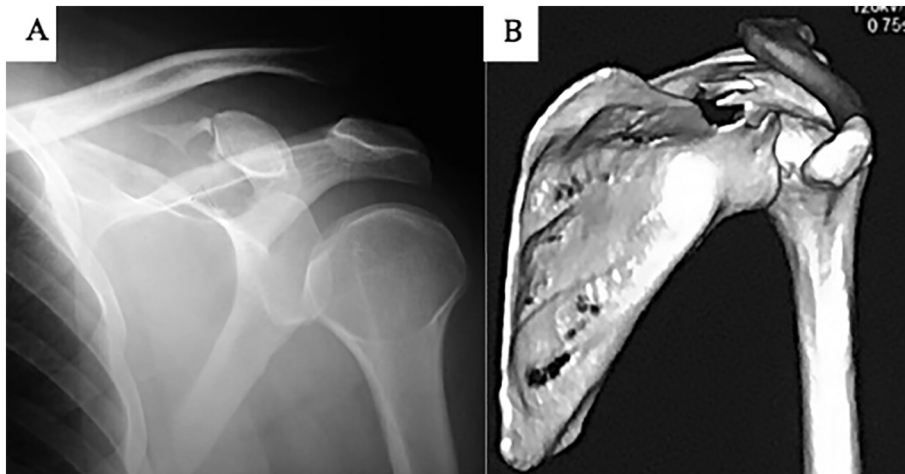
A, B: (A) X-ray of left shoulder showing grade III AC dislocation, (B) 3DCT scan showing comminuted fracture of CP base.
